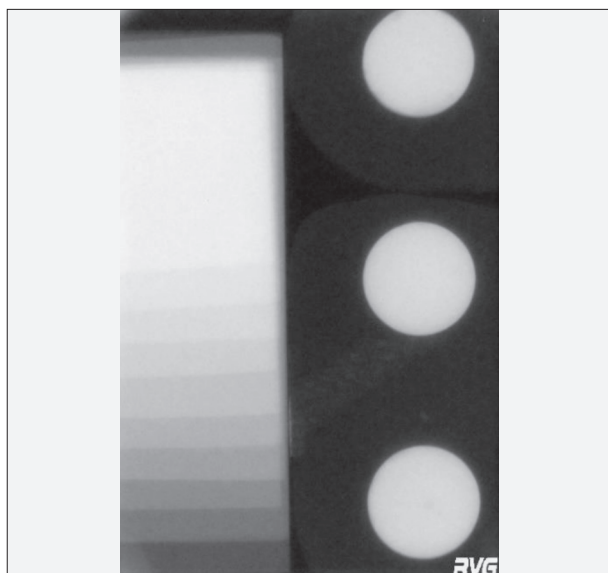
Digital radiographic image of GuttaFlow Bioseal and aluminium stepwedge
